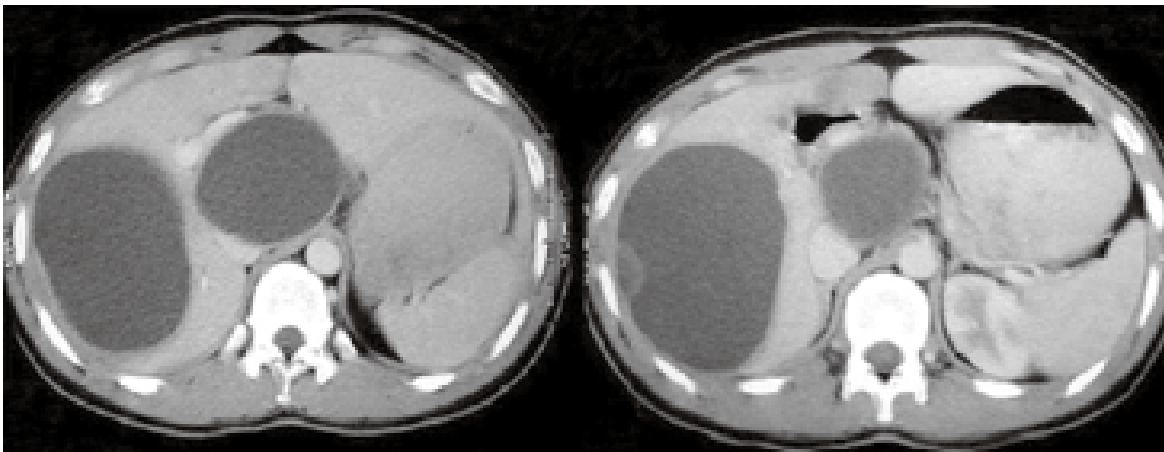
Enhanced axial CT images of the upper abdomen.
